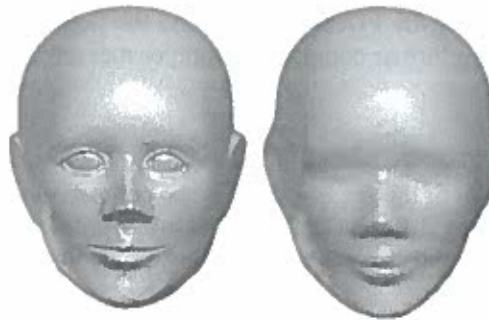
Solid representation of 3DLS (left) and CT (right) data.
